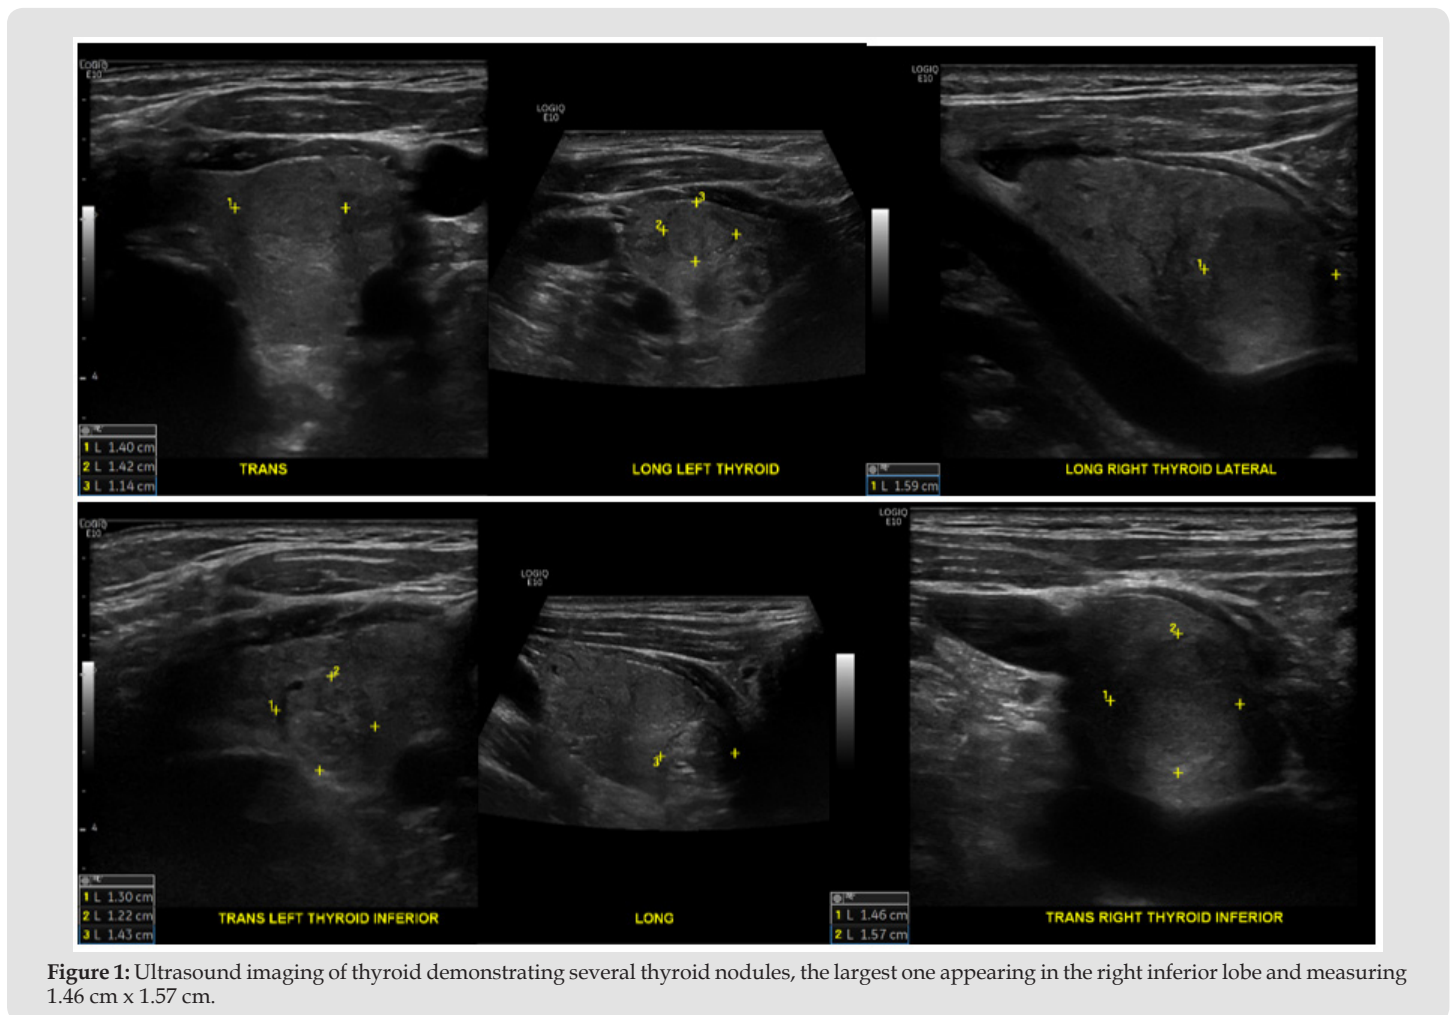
Ultrasound imaging of thyroid demonstrating several thyroid nodules, the largest one appearing in the right inferior lobe and measuring 1.46 cm x 1.57 cm.
